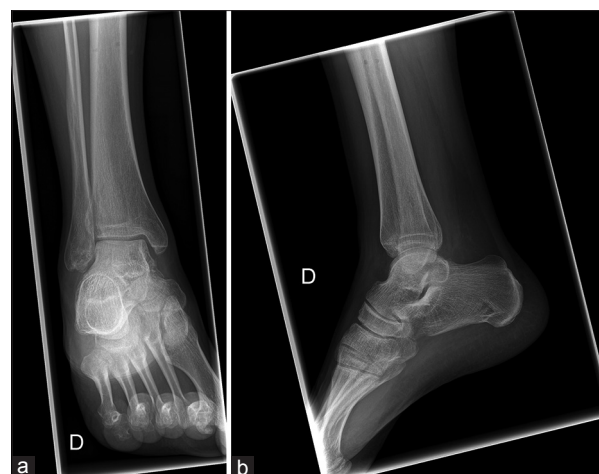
Eighteen months' postoperative radiographs (at the last follow-up) showing a mild superolateral narrowing of the tibiotalar joint space (a) anteroposterior view (b) sagittal view
